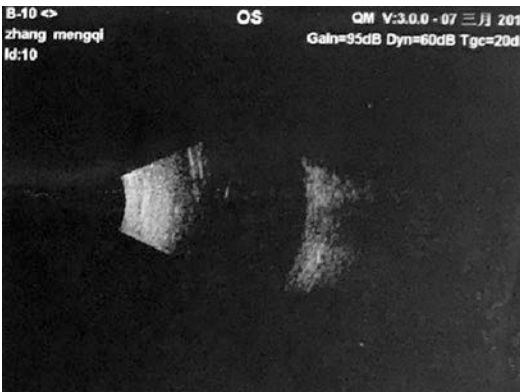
Type-B ultrasonic: normal
